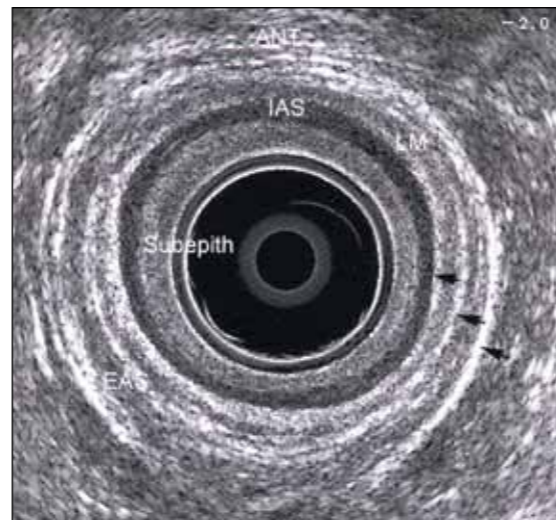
The normal pattern of the anal canal, as depicted by endoanal ultrasound. IAS, internal anal sphincter; EAS, external anal sphincter; ANT, anterior aspect; LM, longitudinal muscle
